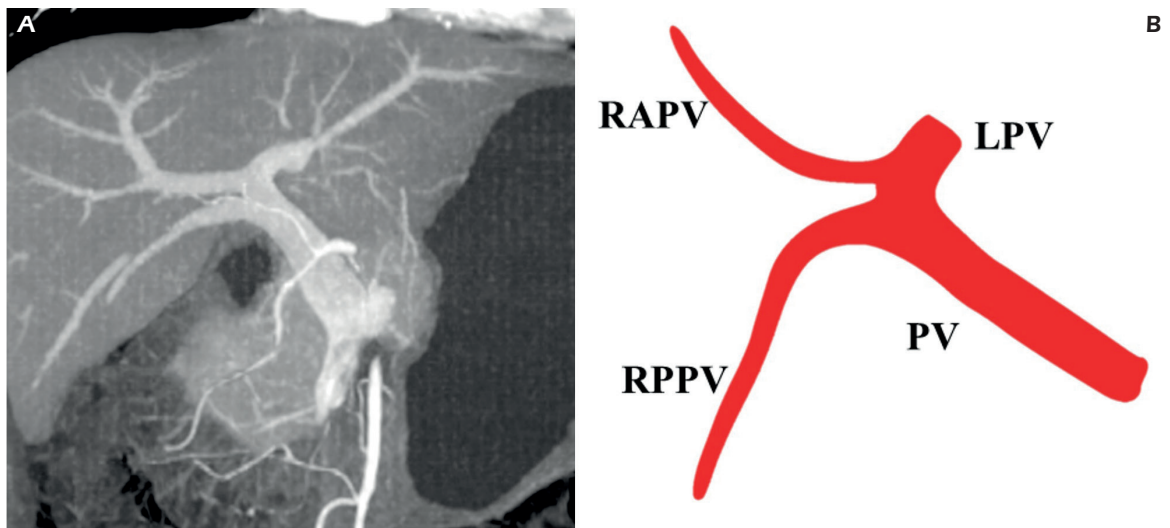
Portal vein variants – type 3. *A*, Contrast-enhanced CT on portal venous phase - coronal MIP reconstruction. The right anterior portal vein originates from the left portal vein. *B*, PV: portal vein; RPPV: right posterior portal vein; LPV: left portal vein; RAPV: right anterior portal vein.
